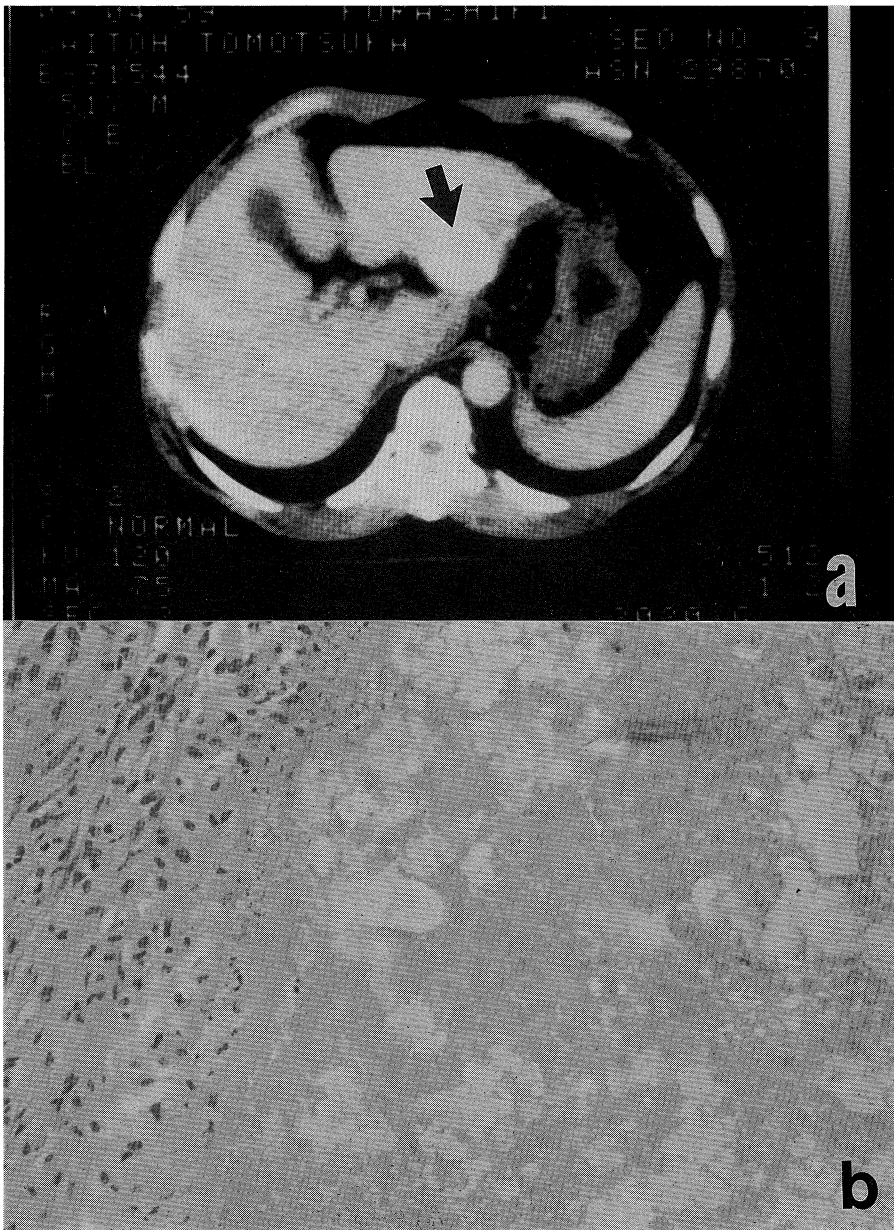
a. A CT scan demonstrates a high density lesion (arrow) in the left lobe of the liver (case 3).
